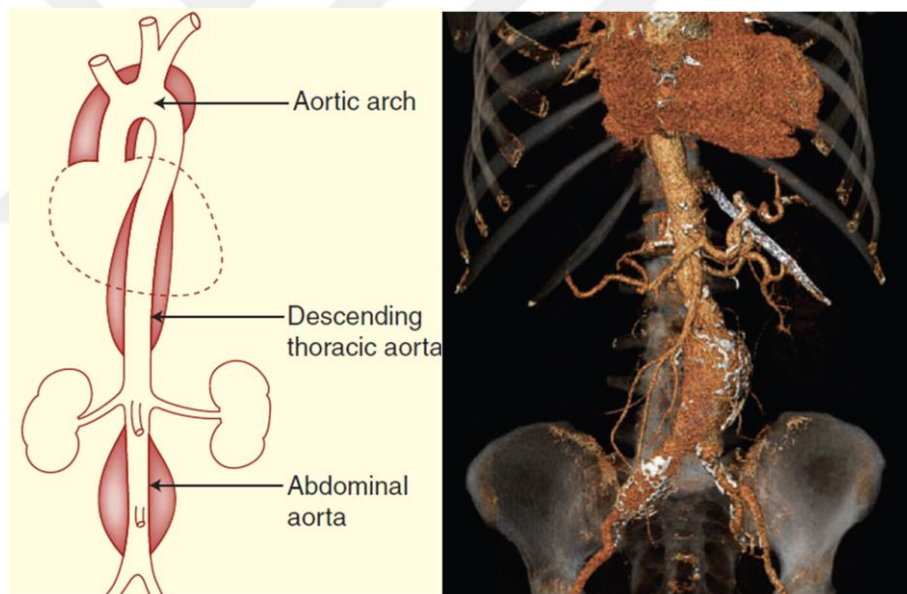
(Left) The structure and aneurysm susceptibility of the human aorta (Kuivaniemi et al., 2015), (Right) CT scan of an AAA taken from a male patient aged 76 years (Nordon et al., 2010)
